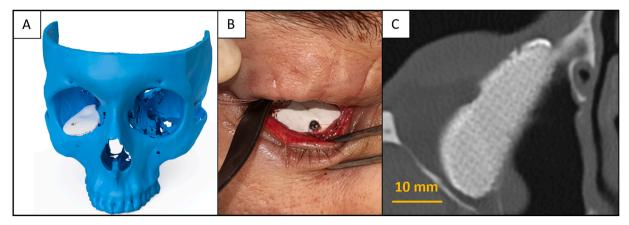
Orbital floor reconstruction — case 12: (A) preoperative planning; (B) intraoperative view of the MBCI; (C) CT scan (sagittal view) of the MBCI at 6 months postoperatively.
